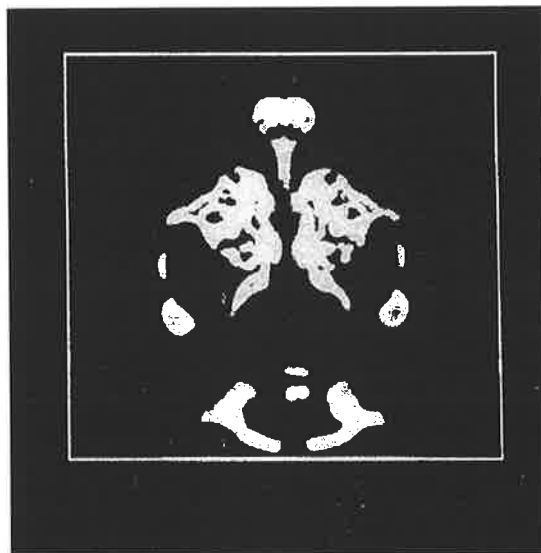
CT slice showing the subregion of interest.
